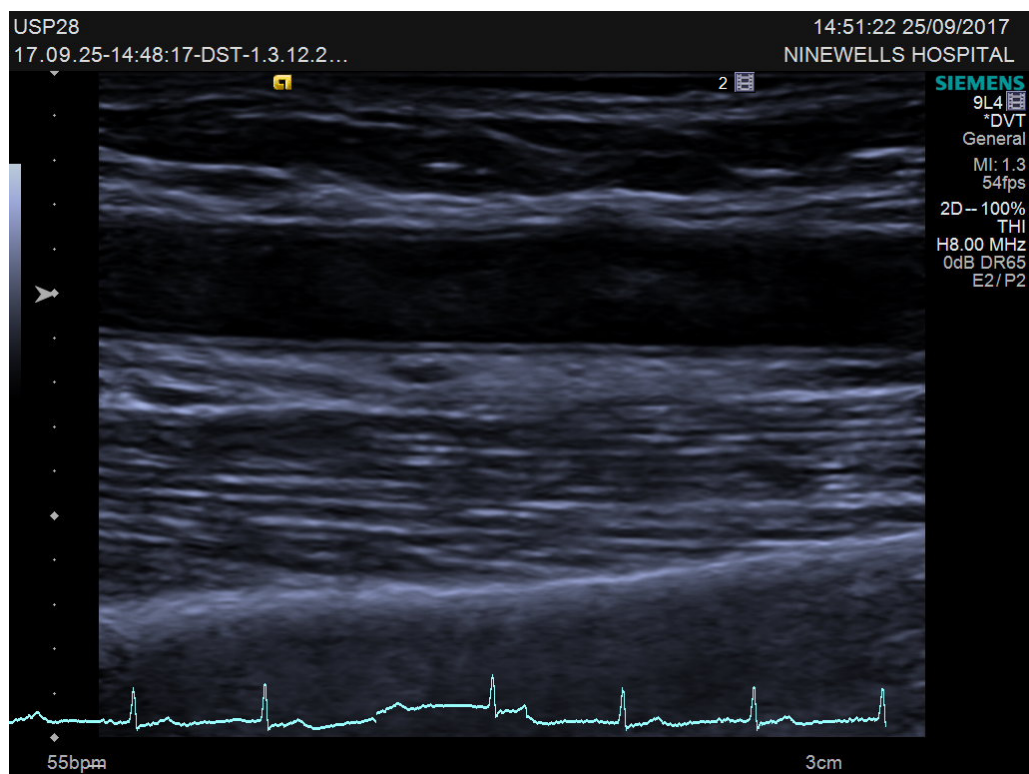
B-mode ultrasound image of a healthy patent brachial artery
